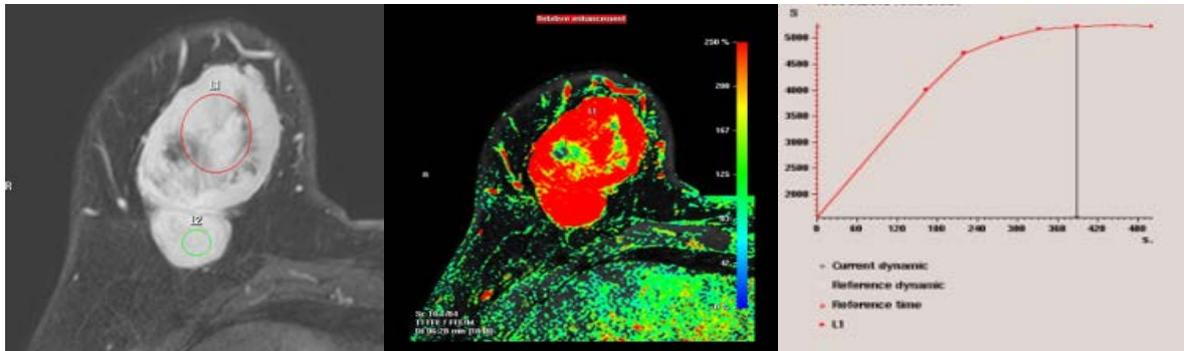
3T MRI image-hyper enhancing lesions strongly perfused and type II curve.
